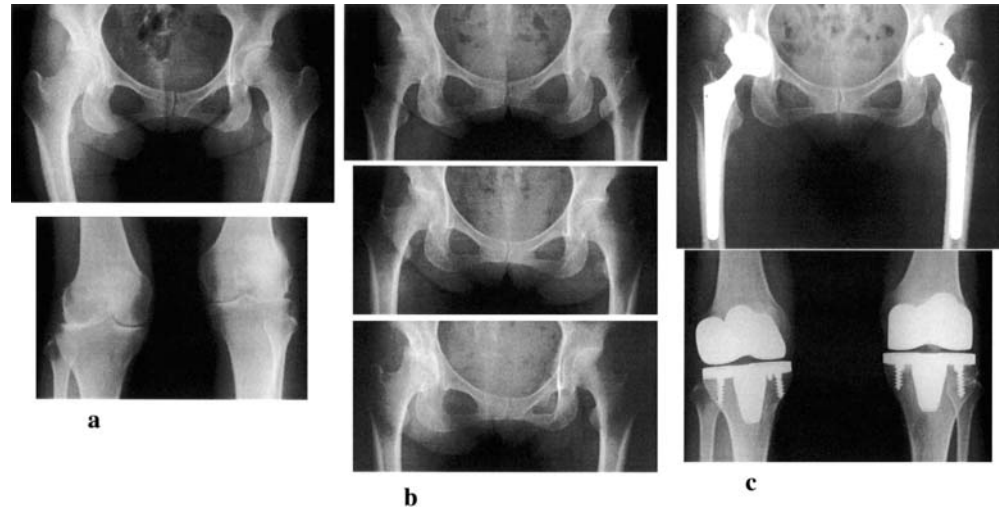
Case 2. a The X-ray finding prior to simultaneous bilateral TKA using Magna ROM21 for bilateral knee joint destruction. No remarkable changes in the hip joints were observed. b The destruction of bilateral hip joints rapidly progressed over the course of 2 months
